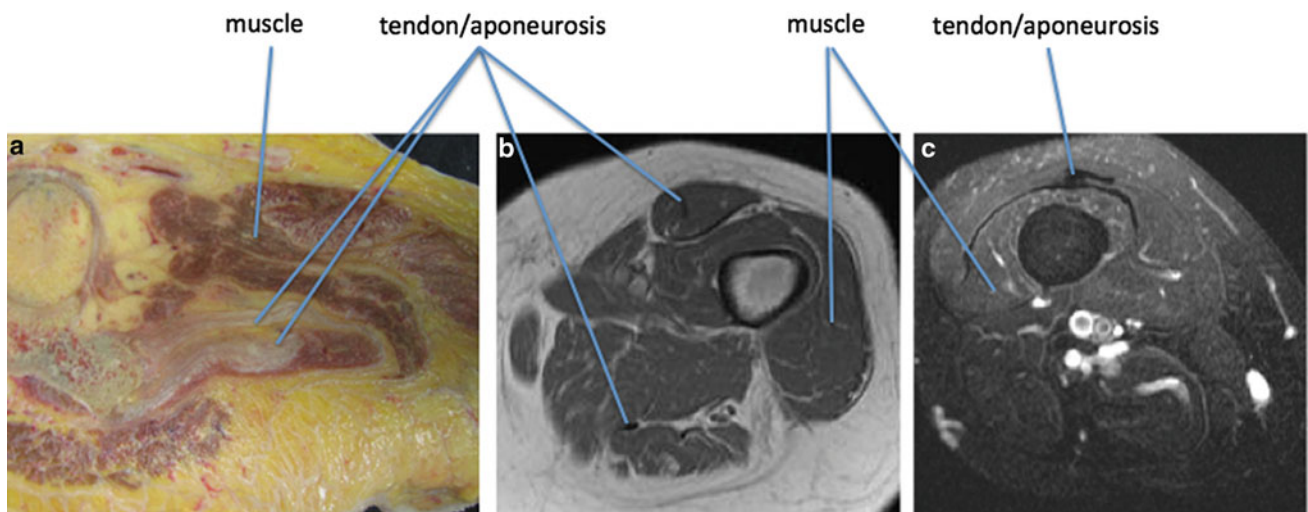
Gross anatomy (a), transverse T1-weighted fast spin-echo (b) and T2-weighted fast spin echo (c) with fat saturation of the human thigh showing the appearance of muscle, tendons, and aponeuroses
